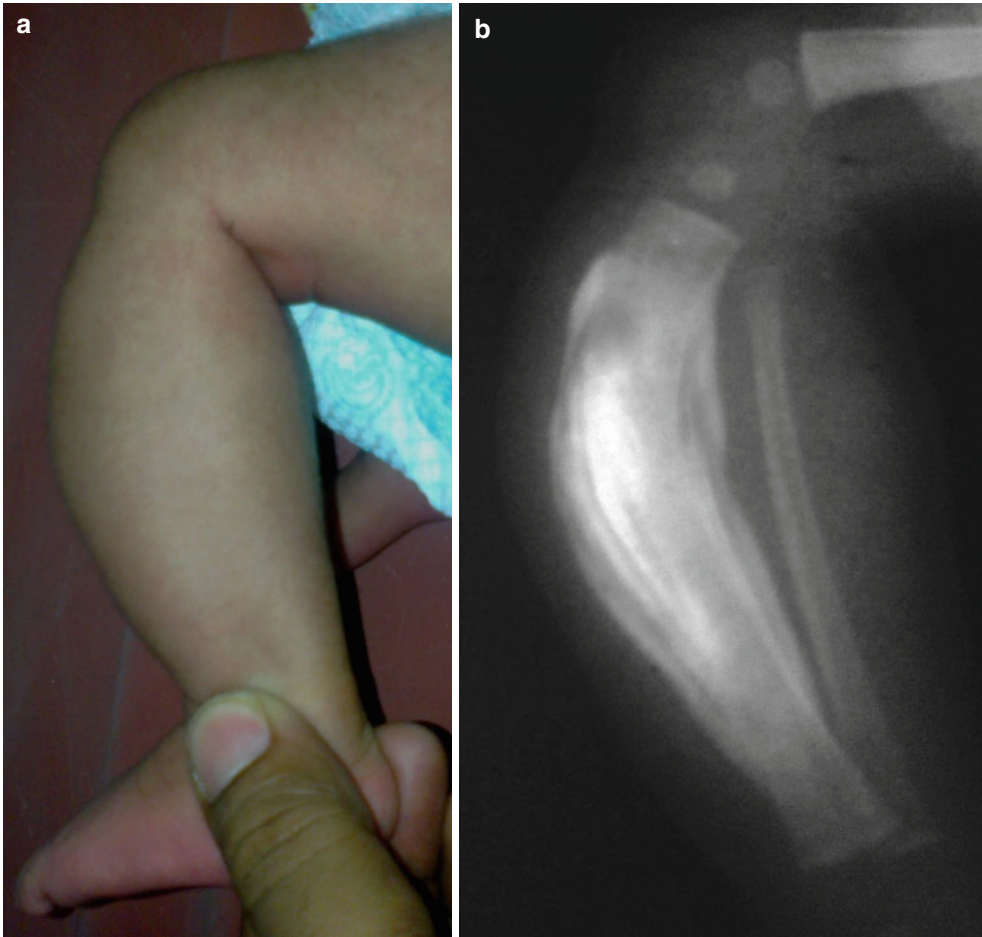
Anterior bowing of the tibia seen in a newborn (a); the leg was warm to touch and slightly tender. The radiograph shows florid periosteal reaction with an onion-peel pattern that is characteristic of Caffey's disease (b) (Courtesy: Dr. Pabitra Sahoo, Cuttack, India)
